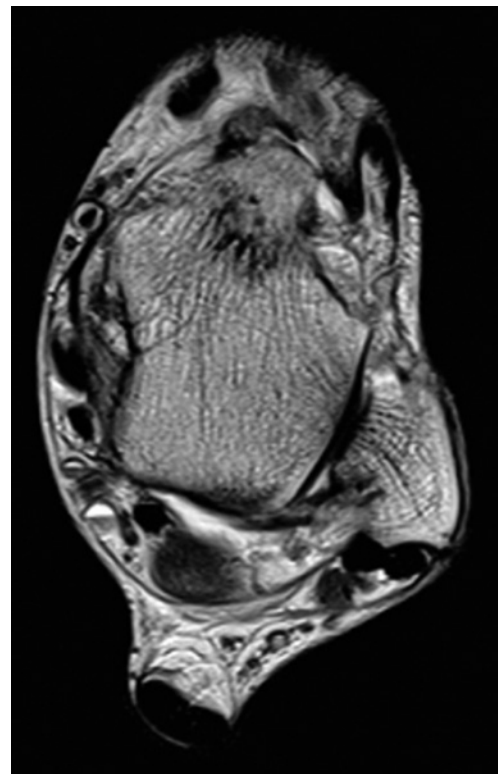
Initial presentation magnetic resonance imaging RI (T2 transverse view) showing subtle thickening of the extensor hallucis longus tendon.
